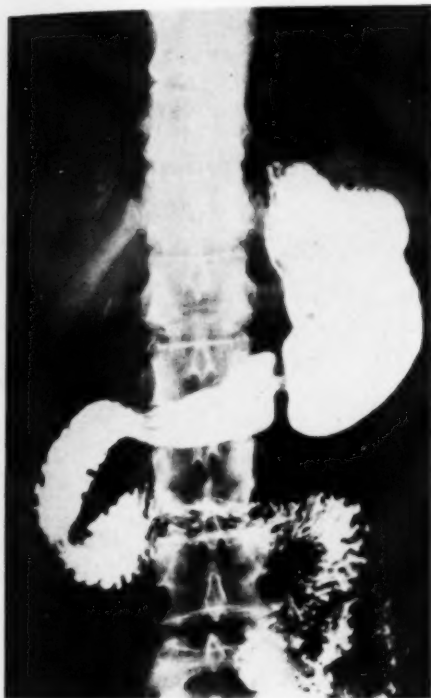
Postoperative roentgenogram (April 1, 1946), showing result of sleeve resection.
